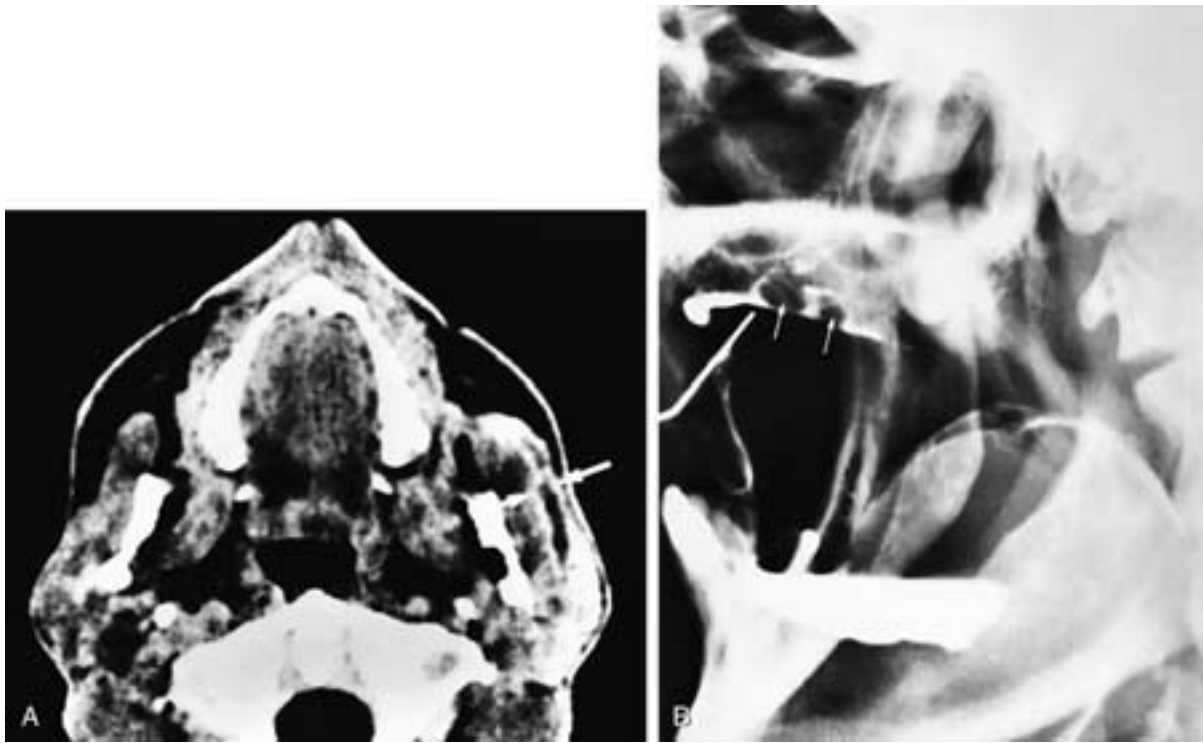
Axial contrast-enhanced CT scan (A) shows increased attenuation in the left parotid gland. There is also thickening and enhancement of the walls of Stensen's duct (*arrows*), and two lower-attenuation areas are present within the dilated duct. A lateral view of the left parotid sialogram (B) on the same patient shows two noncalcified stones in Stensen's duct (*arrows*). This patient had noncalcified sialolithiasis with sialodochitis and sialadenitis.
